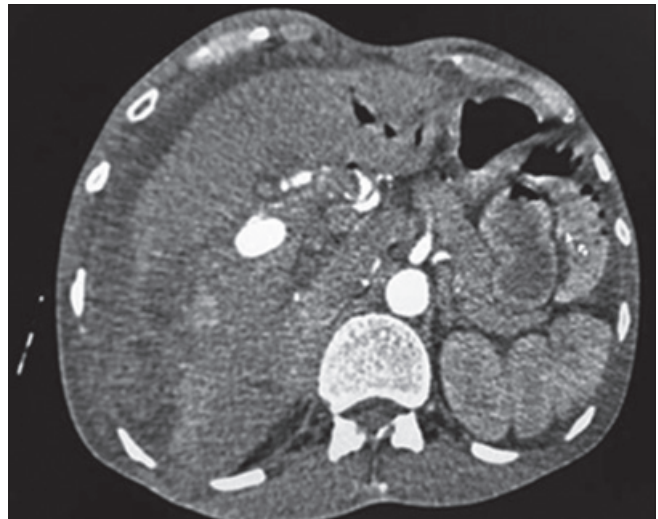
Axial CT showing large pseudoaneurysm of right hepatic artery with parenchymal hematoma in right lobe of liver with subcapsular extension. Air is also noted in left IHBR (PostERCP)
